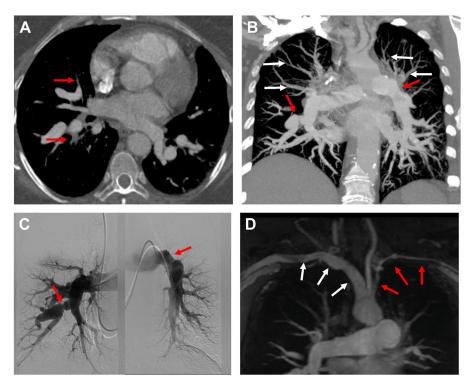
A 59 year old woman with large vessel vasculitis. (*A*) Axial CT pulmonary angiogram image demonstrating diminutive medial segmental artery of the right middle lobe and proximal occlusion at the origin of the right lower lobe lateral and posterior basal segmental arteries (*arrows*). (*B*) Coronal oblique MIP image demonstrates unusual areas of vessel narrowing with beading of the anterior basal segmental artery of the right lower lobe and focal narrowing of the left descending pulmonary artery (*red arrows*). The upper lobe pulmonary arteries are occluded. These findings and distribution would be atypical of CTEPH and are more suggestive of vasculitis. (*C*) Digital subtraction angiography confirmed CT findings with redemonstrated areas of focal narrowing (*arrows*) and occluded upper lobe pulmonary arteries. (*D*) Subsequent MRA demonstrates segmental narrowing of the left axillosubclavian artery (*red arrows*) relative to the right axillosubclavian artery (*white arrows*).
